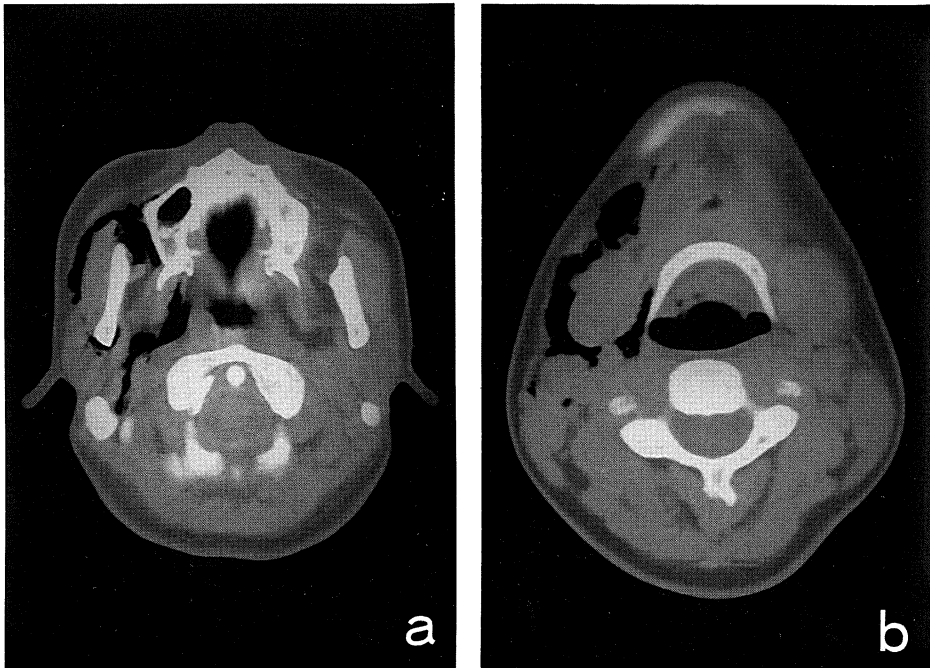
CT image showing emphysema in the perimandibular region, parapharyngeal region(a) and emphysema in the submandibular region(b) on the patient's first visit.
